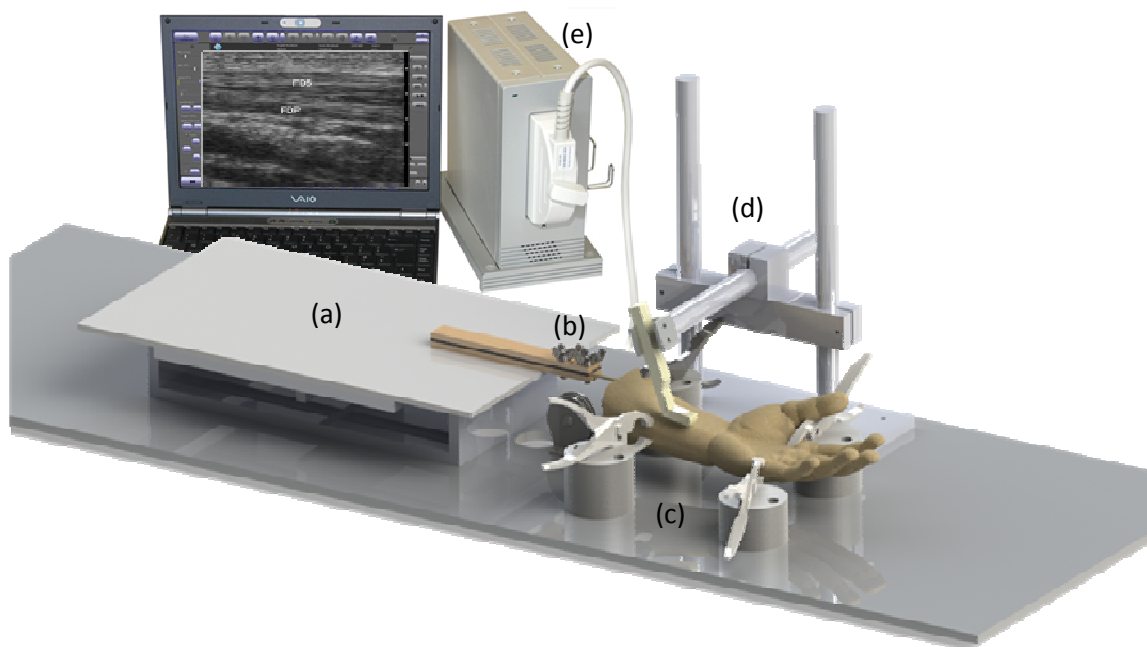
The hardware set-up is comprised of: (a) an actuation system with an x-stage and linear stepper motor (not shown), (b) a tendon coupler, (c) a cadaver stabilization system, and (d) a transducer assembly. Other components include a PC, ultrasound machine, and a standard linear array transducer, as shown in (e).
